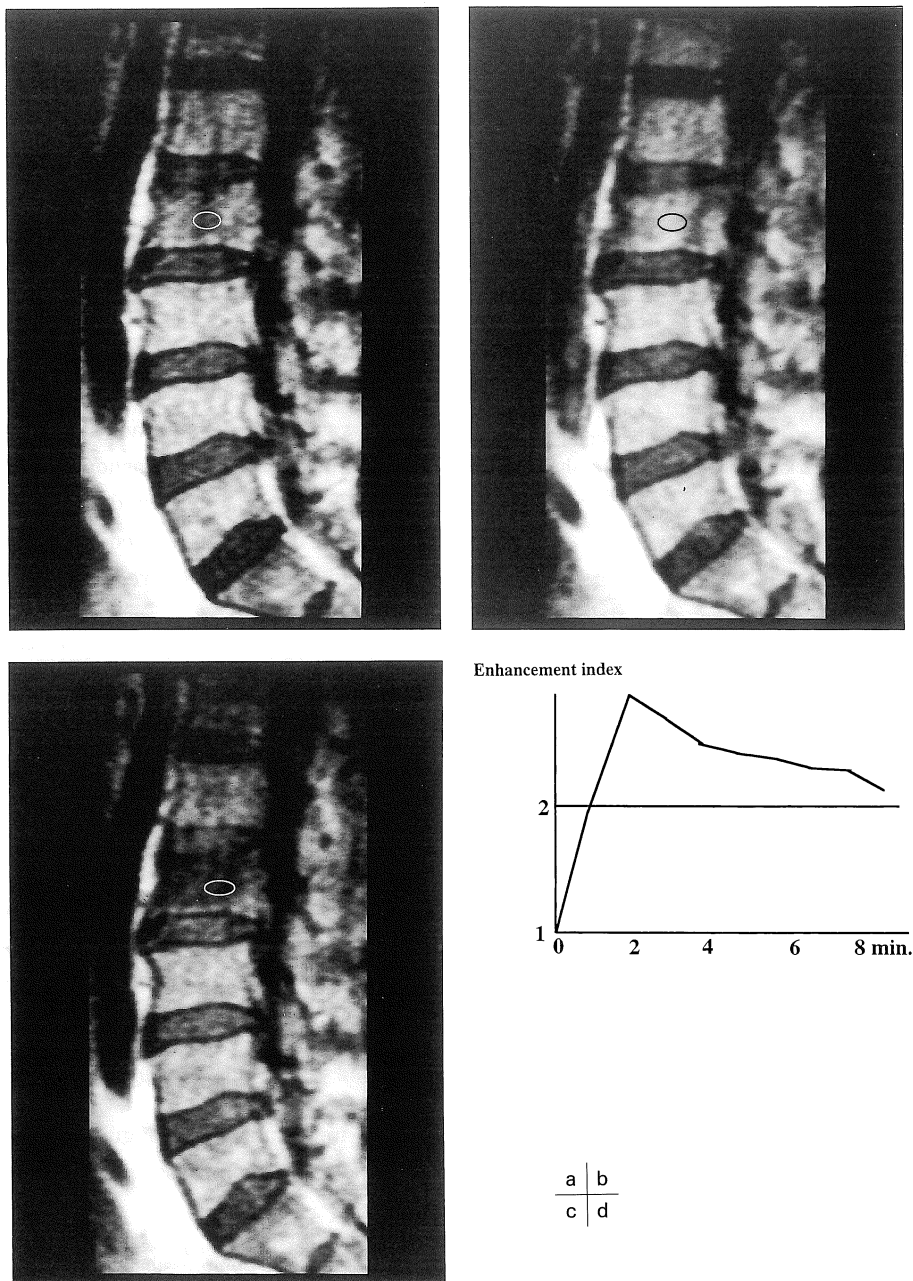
Dynamic MR images of metastatic compression fractures of vertebral bodies. The primary tumor was colon carcinoma. An elliptically region of interest was plotted in compressed vertebral body.
